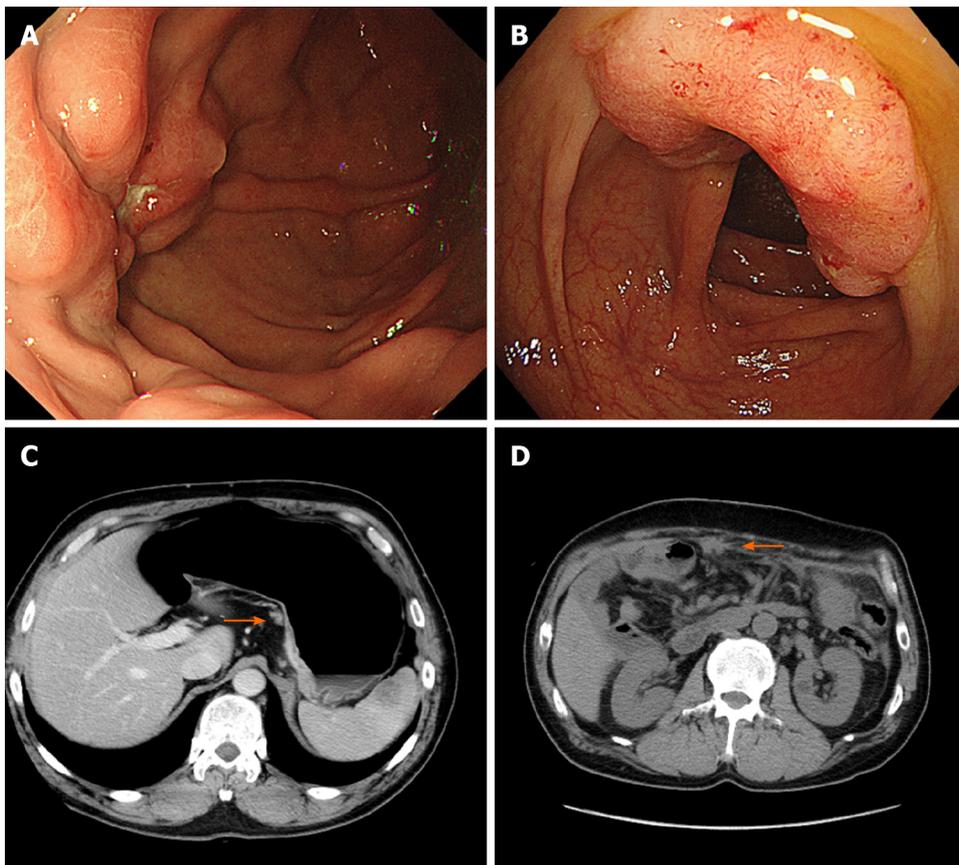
Representative images obtained from esophagogastroduodenoscopy, colonoscopy and computed tomography in Case 2. A: Advanced gastric cancer was observed at the fundus in esophagogastroduodenoscopy; B: Colonoscopy showed advanced colon cancer at the ascending colon; C: Metastatic lymph nodes at the lesser curvature of the proximal stomach without distant metastasis were identified by abdominal computed tomography (CT) (orange arrow); D: Peritoneal dissemination were observed by abdominal CT during the adjuvant chemotherapy (orange arrow).
